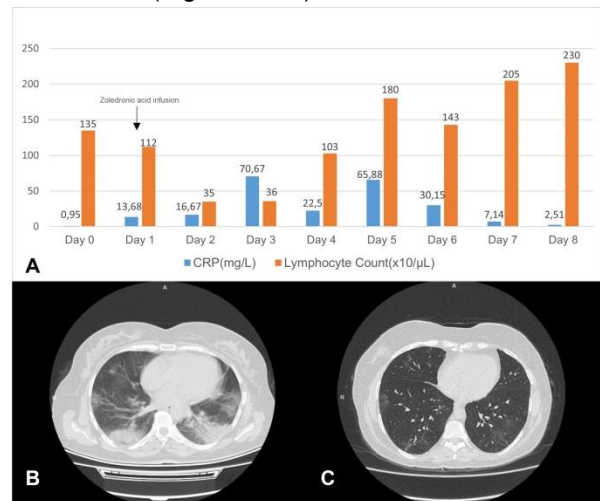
A. Changes in CRP and lymphocyte count before and after zoledronic acid infusion 1 B-C: High Resolution Computer Tomography (HRCT) images of lungs at the time of COVID-19 and images of lung showing regression of ground glass opacities after COVID-19.
